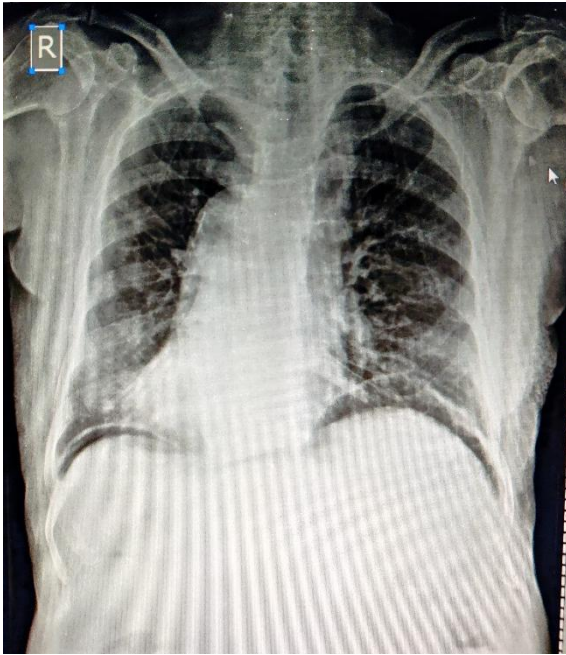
XRAY Erect Abdomen showing gas under both domes of diaphragm.
